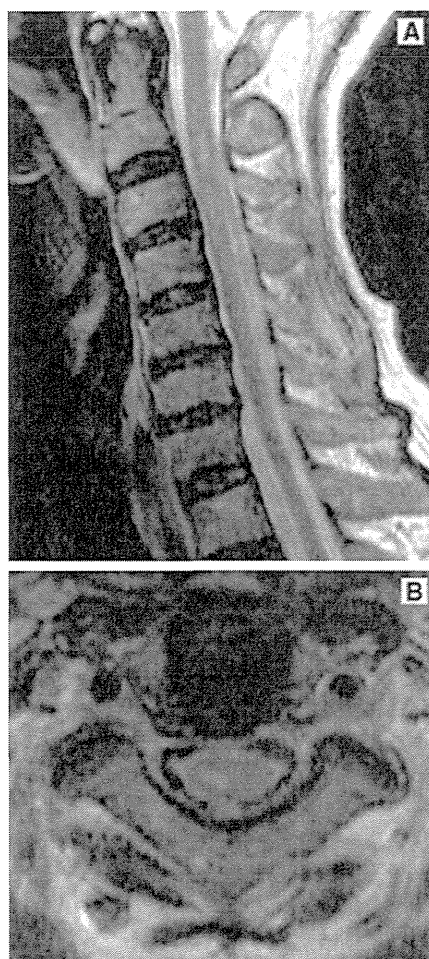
Cervical-cord MRI findings of patient 2 (T2-weighted imaging). T2 prolongation in the sagittal section at the C2–3 level (a), and T2 prolongation in the right intramedullary area in the axial section (b) were observed. These findings are consistent with myelitis
